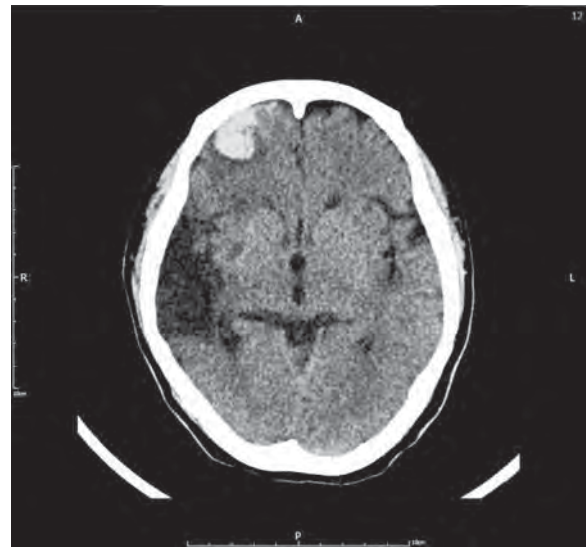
Without-contrast CT image shows a $2.1 \times 1.9 \text{ cm}^2$ hyperdense lesion in the right anterior frontal lobe as well as a surrounding hypodense area, indicating acute intracranial hematoma with perifocal edema.
